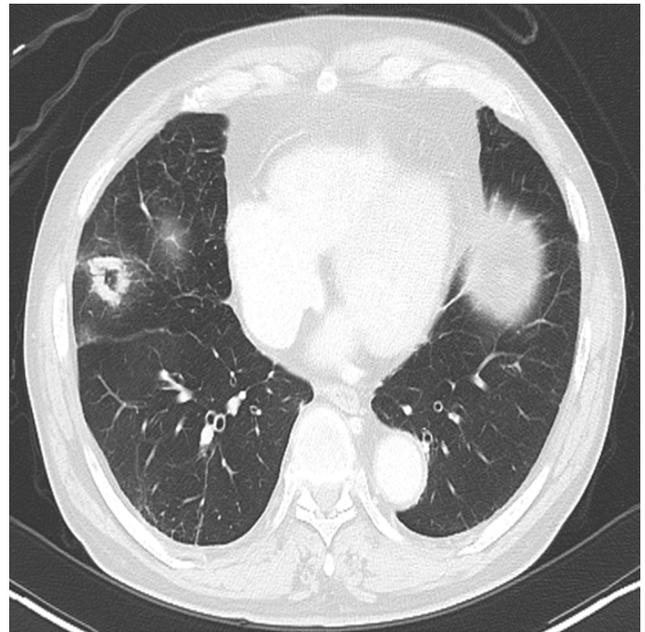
A CT scan after 2 years and 5 months of erlotinib treatment showed that the new lesion was much larger.
